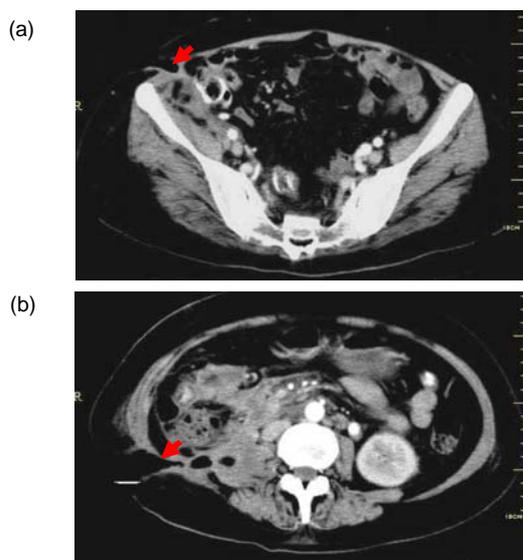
Abdominal incision (a) and lumbar incision (b) on CT (arrow)
